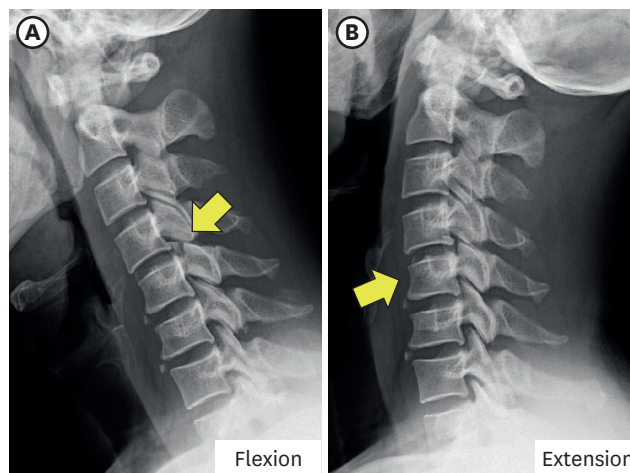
C-spine dynamic X-ray images before the discharge. Flexion (A) and extension (B) images showed no sign of dislocation or subluxation (yellow arrow: C5 vertebra).
